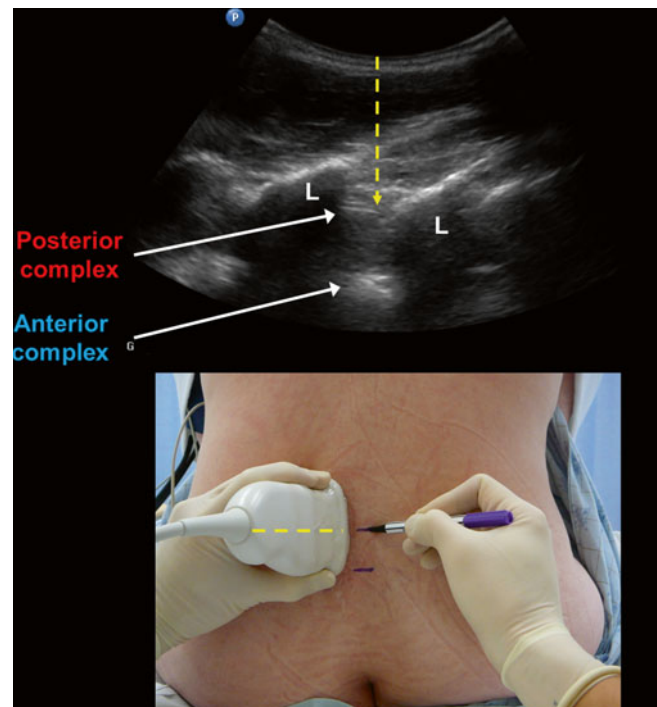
In the parasagittal oblique view, each interlaminar space is centered in turn on the ultrasound screen. A corresponding skin mark is made at the midpoint of the probe’s long edge to mark its position (Courtesy of www.usra.ca)
